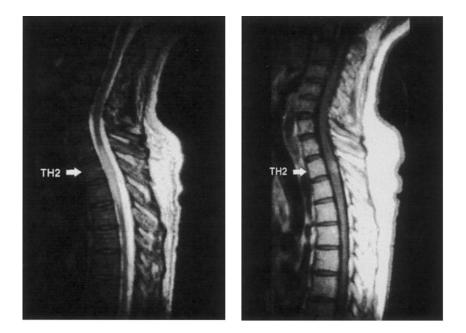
Spinal MRI scan, October 1996. Left panel, Sagittal T2-weighted fast spin echo sequence: increased cord diameter with high signal intensity from the first to fourth thoracic vertebra. Right panel, Sagittal T1-weighted fast spin echo sequence after gadolinium chelate injection: nodular contrast enhancement with irregular contours in the dorsal cord at the level of the second thoracic vertebra.
